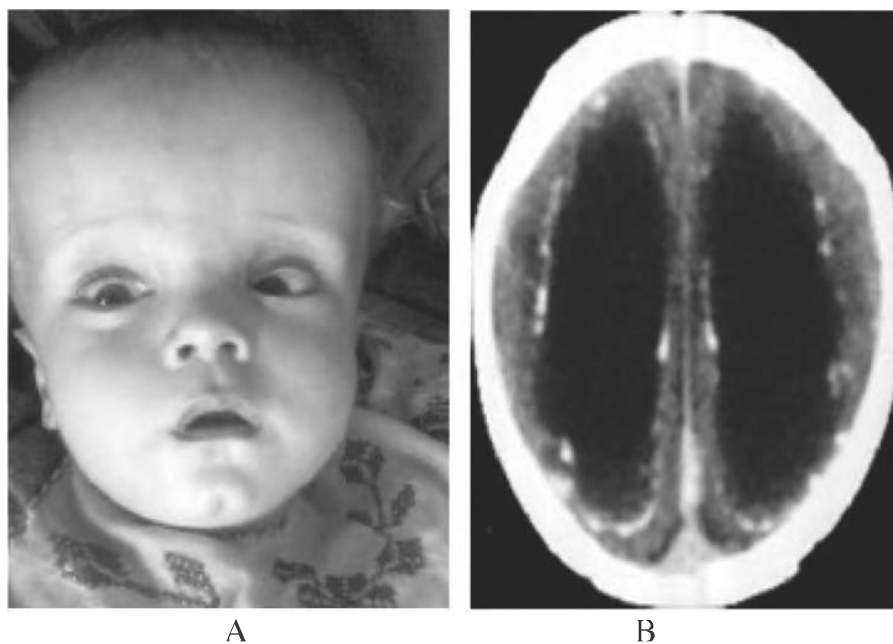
Infant with hydrocephalus (A). Brain CT scan show dilated ventricles and calcification
